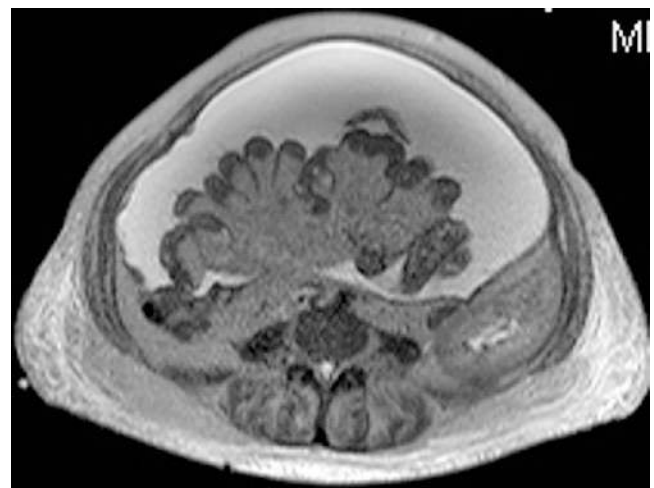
CT scans demonstrating free fluid, thickening of both parietal and visceral peritoneum with certain areas of calcification, mesenteric retraction and some gut dilatation. The first image is of a patient with post-transplant EPS and there is a good functioning kidney in the left flank
